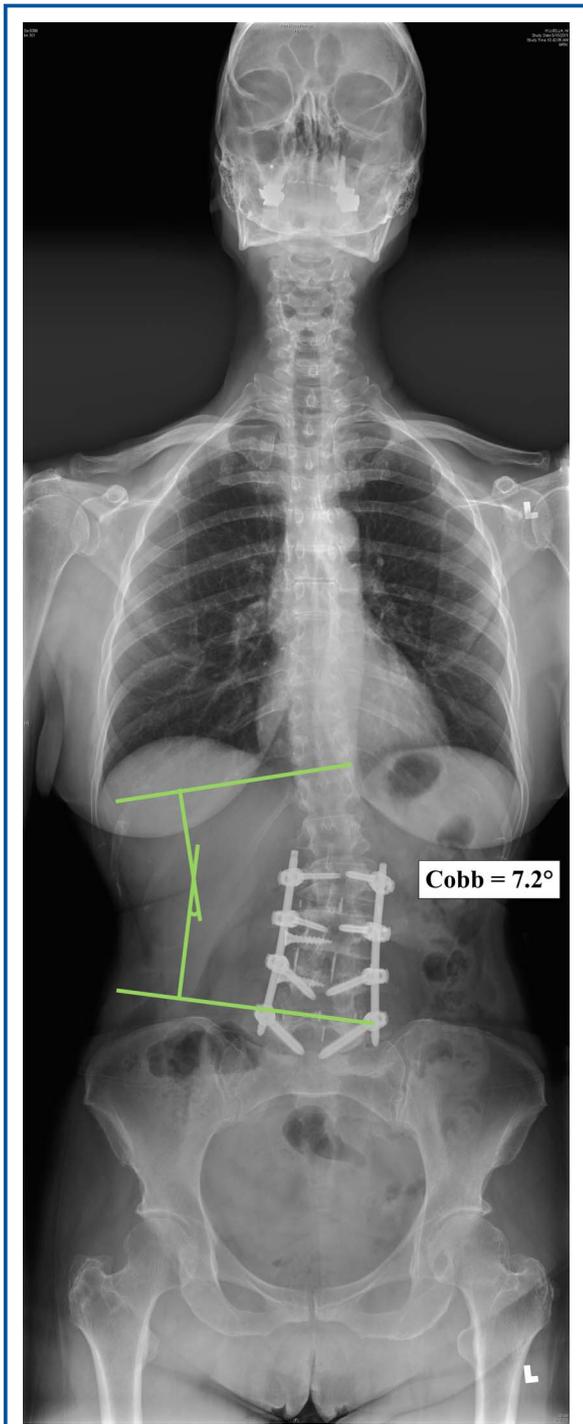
Postoperative 36-inch anterior-posterior (AP) radiograph with spinal parameters. Color version available online only.
